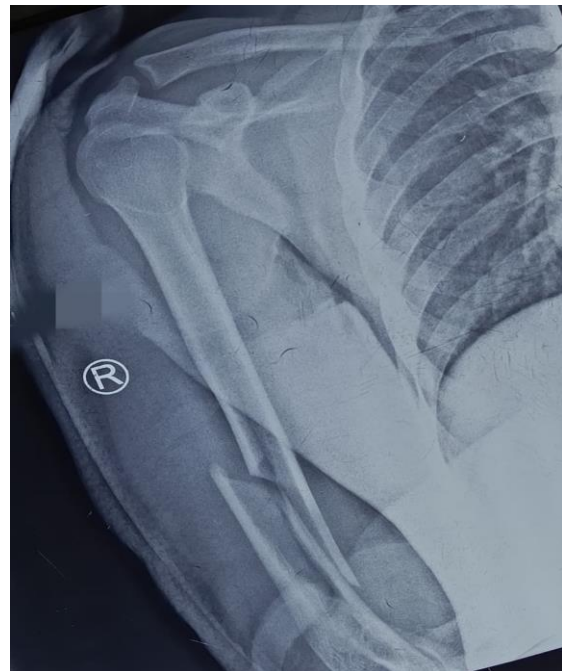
pre-operative radiographs showing fracture of distal humerus*
